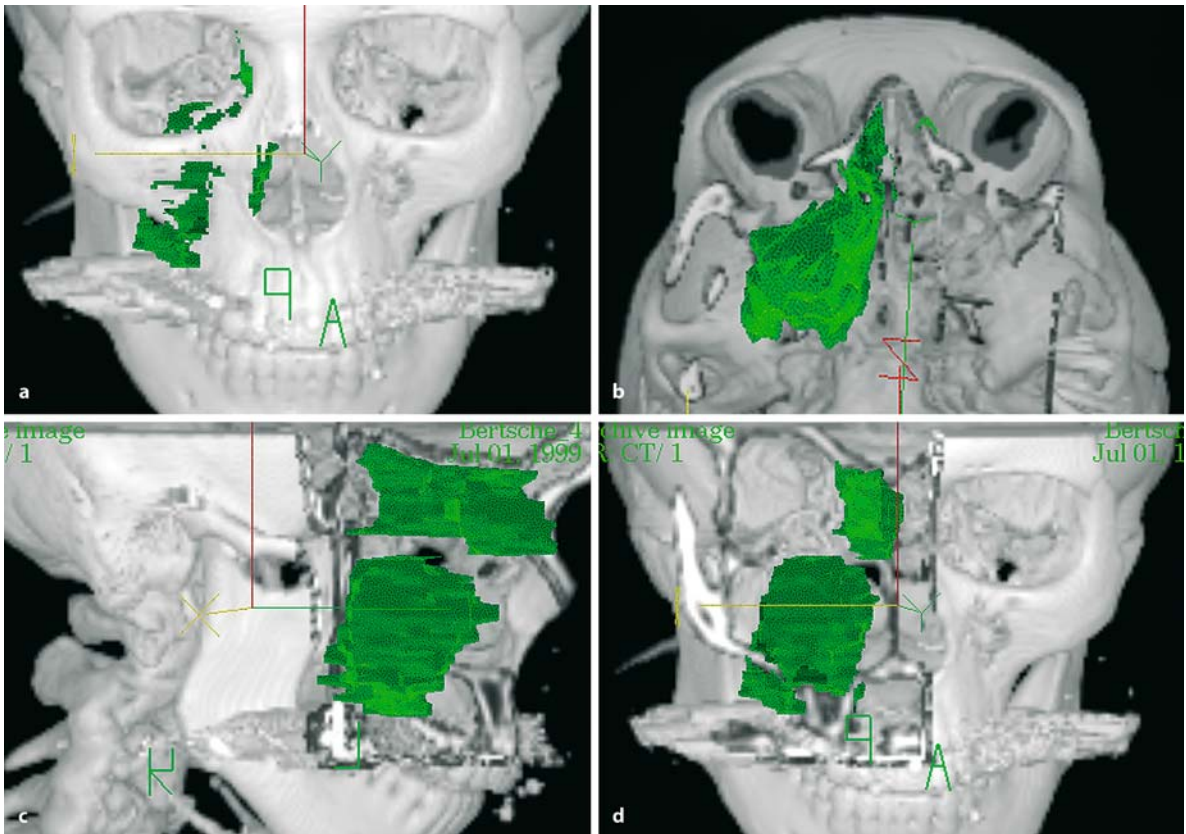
Anaplastic carcinoma of the right maxillary sinus. Visualization of the tumor volume in a 3D reconstruction of the CT data set allows for detailed planning of the resection and reconstruction
